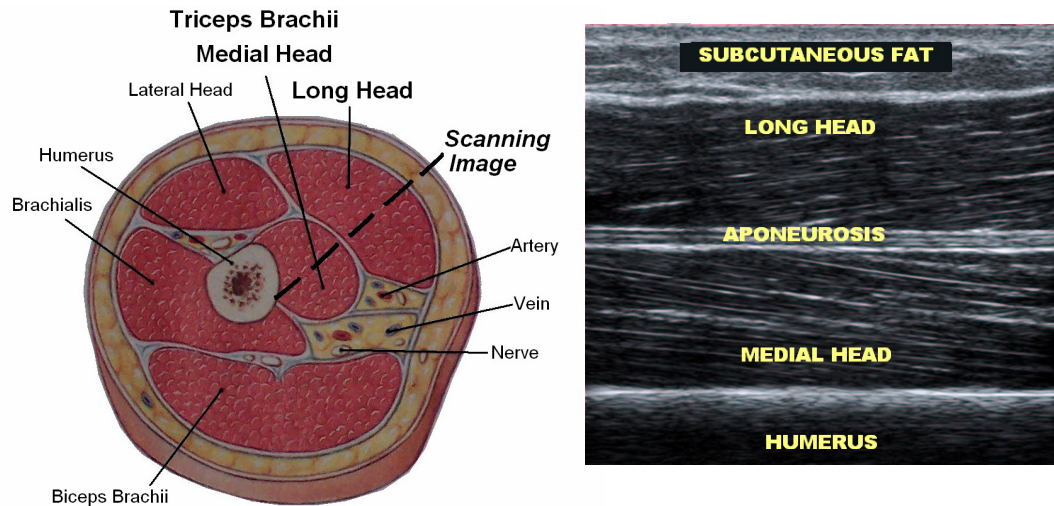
Ultrasound scan of the medial and long heads of the triceps brachii, with important architectural features labelled.
